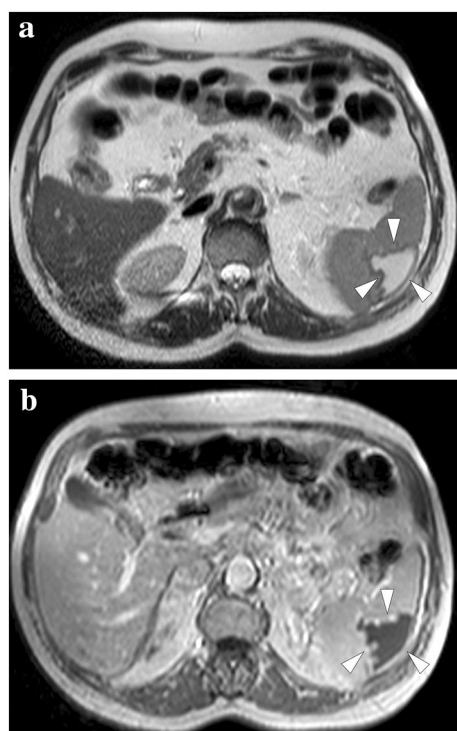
A 63-year-old male with previously diagnosed splenic infarction due to atrial fibrillation in an outside institution. a and b Axial plane T2 and post-contrast T1-weighted MR images, respectively, showed peripherally located, triangular-shaped, well-demarcated, T2-hyperintense, and T1-hypointense nonenhancing parenchymal area (arrowheads). These findings were found to represent cystic-liquefying changes in the subacute phase
